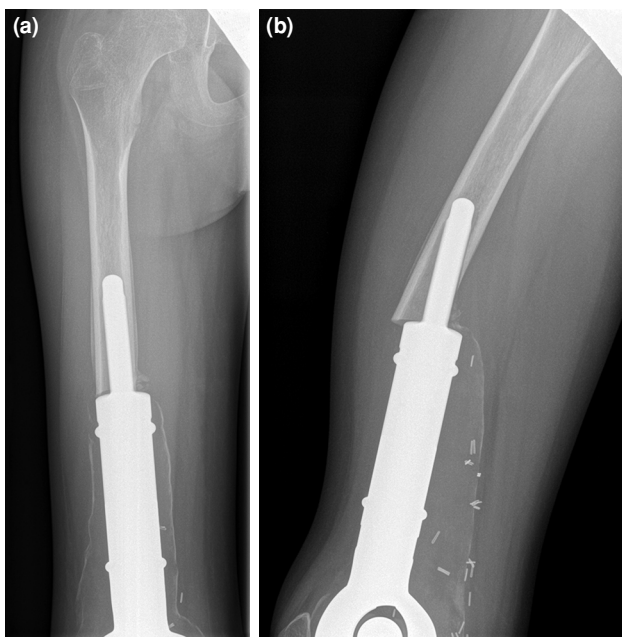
Aseptic loosening half a year after implantation. (a) Anteroposterior radiograph (b) lateral radiograph.
